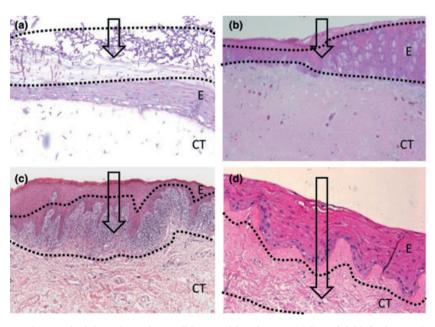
Level of drug penetration required depends on the condition requiring therapy. (a) Superficial infections such as candidiasis do not need to cross the permeability barrier. (b) Mucosal diseases such as dysplastic lesions require retained delivery to the affected epithelium. (c) Oral lichen planus affects basal cells and the adjacent connective tissue and requires delivery to these cells. (d) For systemic delivery, the therapeutic agent needs to cross the permeability barrier and should not be retained in the epithelium. Arrows show level of penetration required. Dotted lines show the desired area for drug retention. E, epithelium; CT, connective tissue
